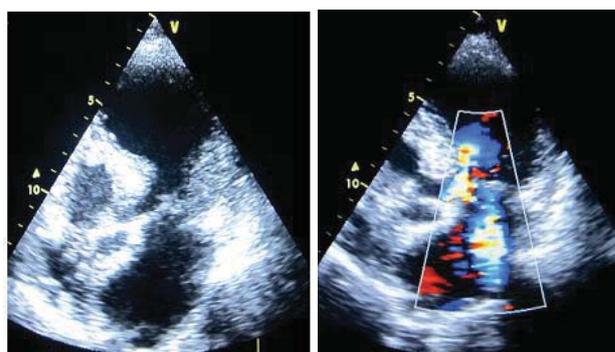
Two-dimensional echocardiography in takotsubo cardiomyopathy showing a typical apical ballooning configuration of the left ventricle (LV) in systole, and significant mitral regurgitation.
